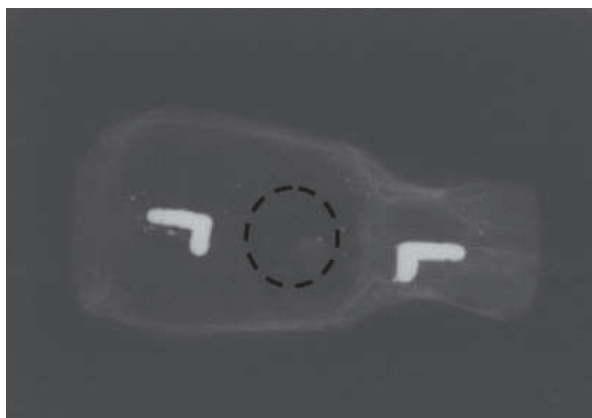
Scanned periapical radiograph showing the wounded area (circle)
